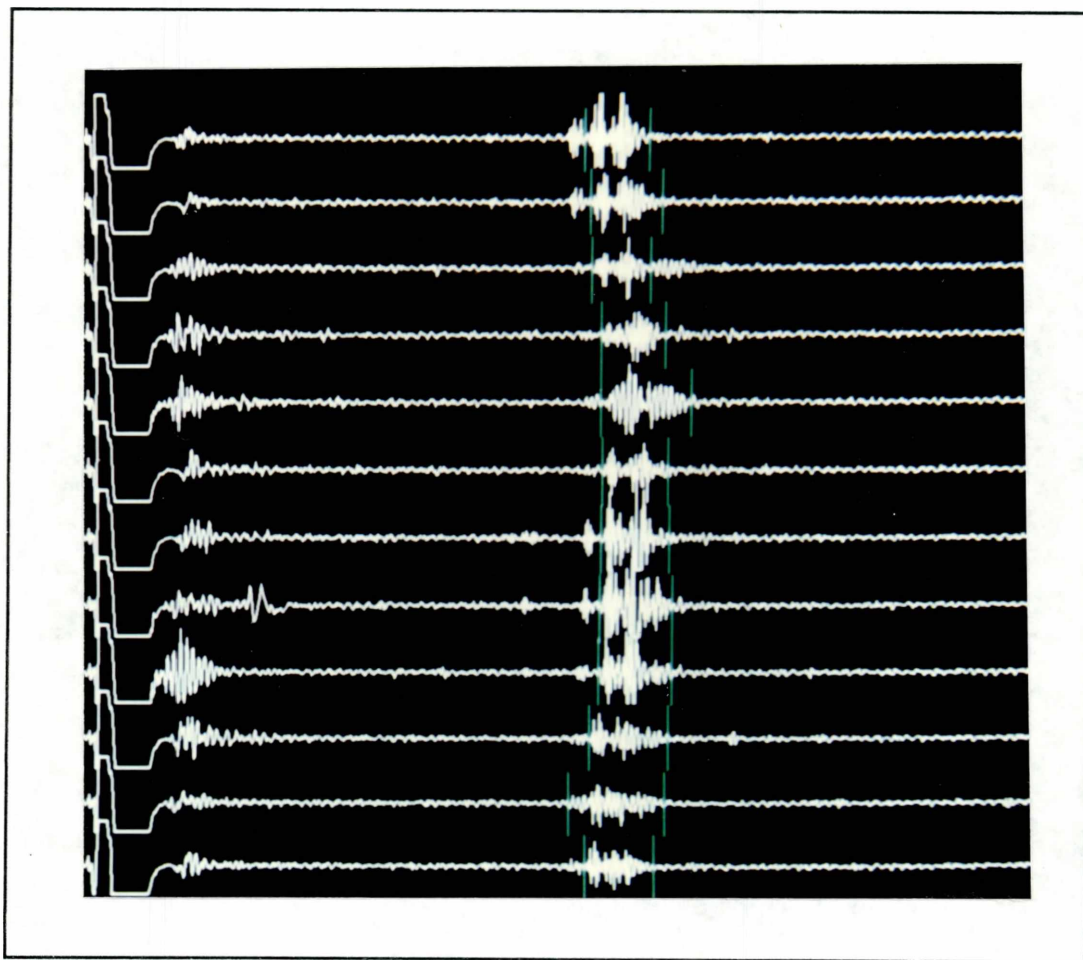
12 ultrasound signals captured by the miniature ring array transducer.
